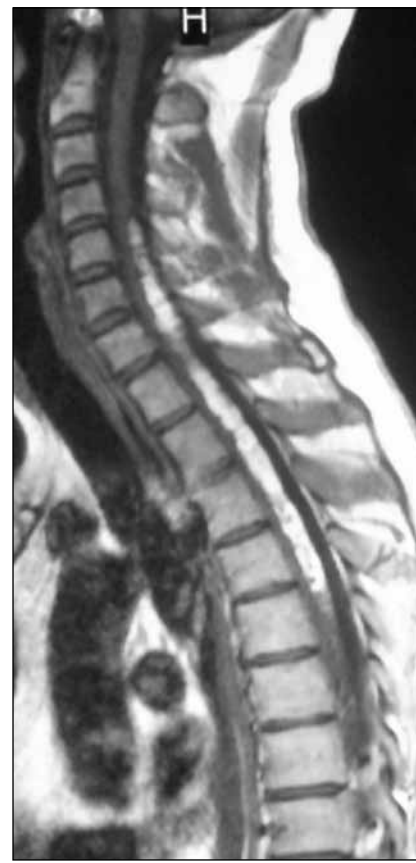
Sagittal T-1 MR images showed a huge syrinx cavity with hyperintense fat content from C-4 to T-5.
